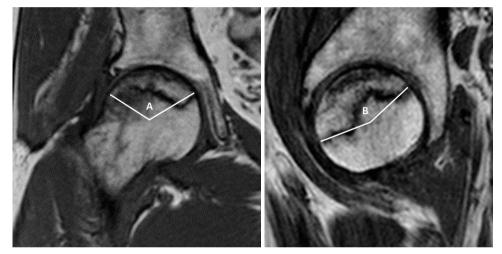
Modified Kerboul classification system of femoral head osteonecrosis. A: necrotic angle in mid-coronal MR image. B: necrotic angle in mid-sagittal MR image. Combined necrotic angle: A + B. Three categories: small lesion (combined necrotic angle \leq 190°), medium-sized lesion (combined necrotic angle between 190° and 240°), and large lesion (combined necrotic angle \geq 240°). MR = magnetic resonance.
